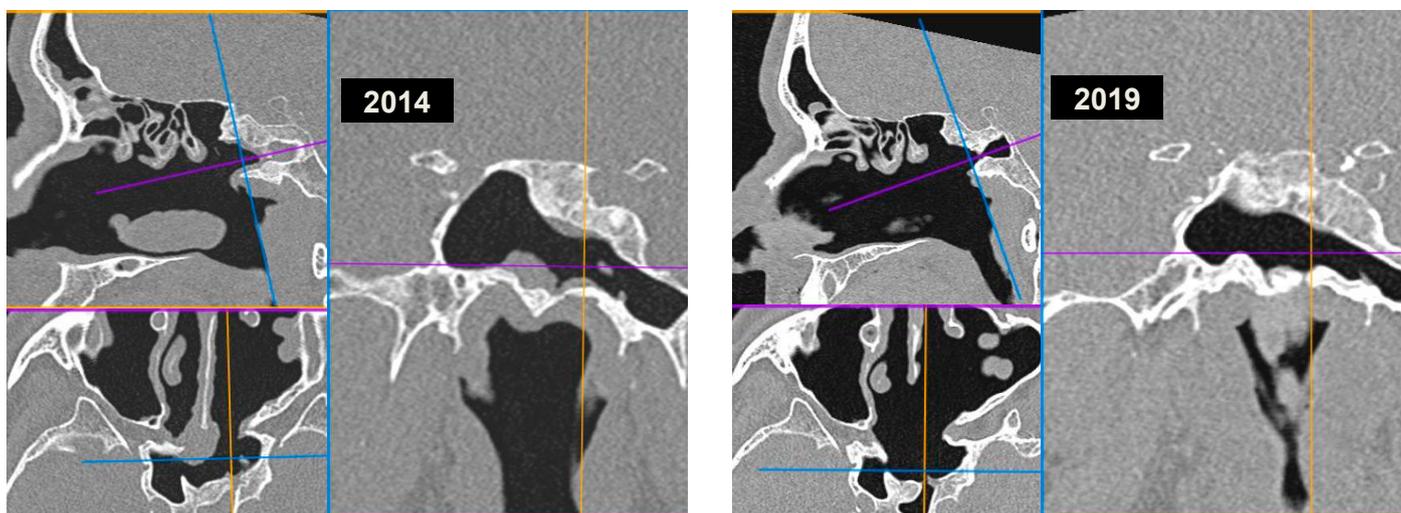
(A, B) Preoperative CT and post-operative MRI scans after a Draf 2b.3 procedure (Draf 2b access extended to include the removal of the upper part of the nasal septum and the lower part of the intersinus septum) in a patient with inverted papilloma of the left frontal sinus.
